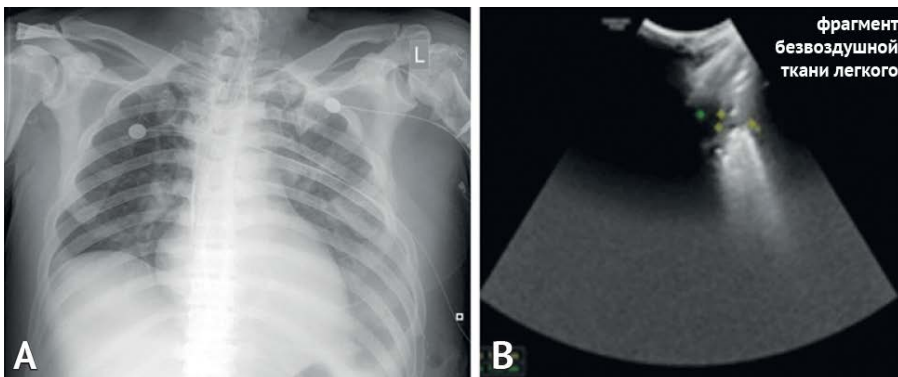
A — chest X-ray. Hypoventilation in the lower sections on the left, hydrothorax on the left, a humerus fracture on the left; B — ultrasound image of the airless lower lobe of the left lung (contusion)
